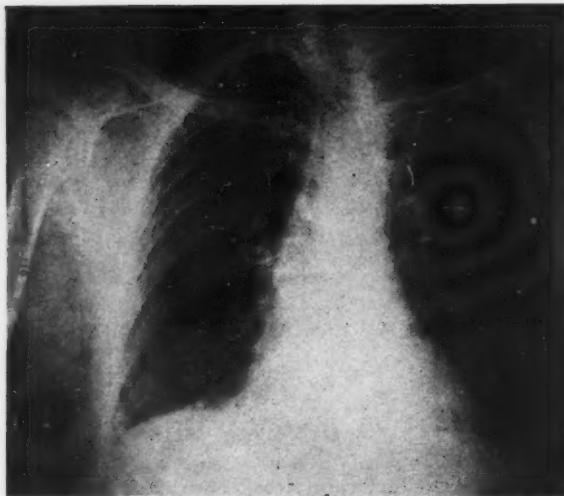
Chest roentgenogram of Case I, H. L., six months after onset of symptoms.
